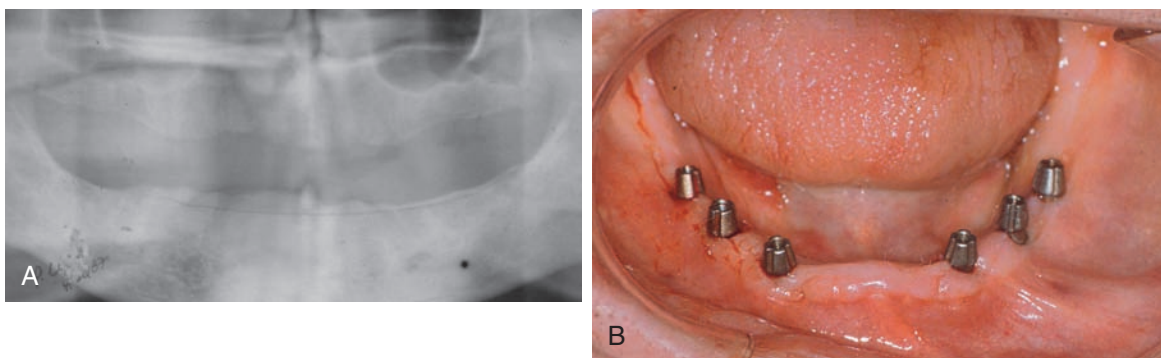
A, Panoramic radiograph of edentulous mandible well suited for immediate load over denture. B, Flapless procedure for placement of six one-piece, single-stage implants.
